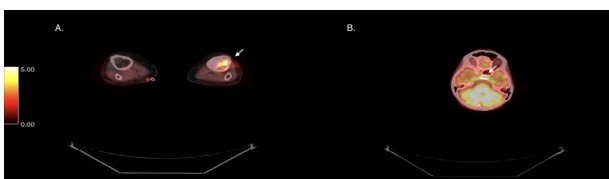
(A) 18-FDG PET/CT image showing increased fluorodeoxyglucose uptake of the proximal tibia. (B) 18-FDG PET/CT image showing increased fluorodeoxyglucose uptake of the sella turcica.
